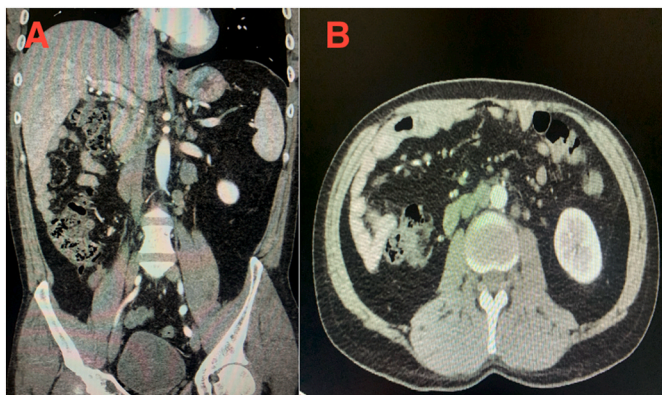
A; Coronal CT scan demonstrating inter-aortocaval lymphadenopathy (up to 2cm in diameter). B; Axial CT scan demonstrating para-aortic lymphadenopathy (up to 2cm in diameter).
